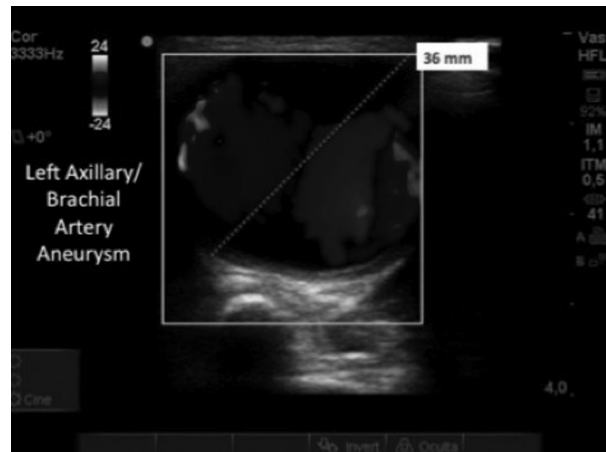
Preoperative Doppler ultrasonography showing an arterial aneurysm in the transition between left axillary and brachial arteries.
